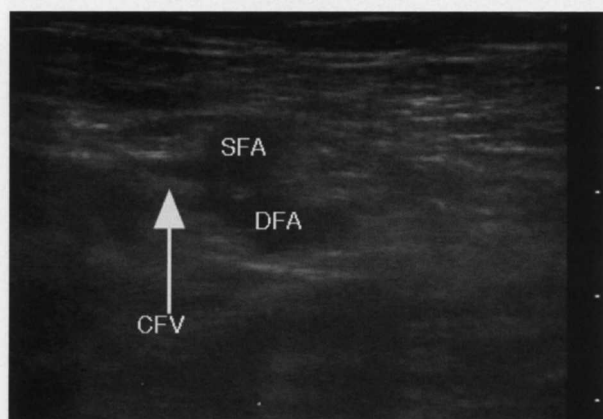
Ultrasound showing normal compression of the left common femoral vein (CFV). (Superficial femoral artery: SFA; Deep Femoral Artery: DFA.)
